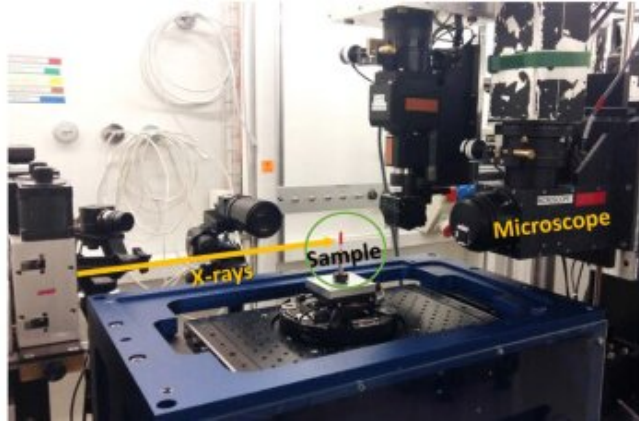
An SXR-PhC- $\mu$ CT imaging set-up from the TOMCAT beamline of the Swiss Light Source, obtained at an experiment where the feasibility of SXR-PhC- $\mu$ CT for meniscus imaging was studied [6].
